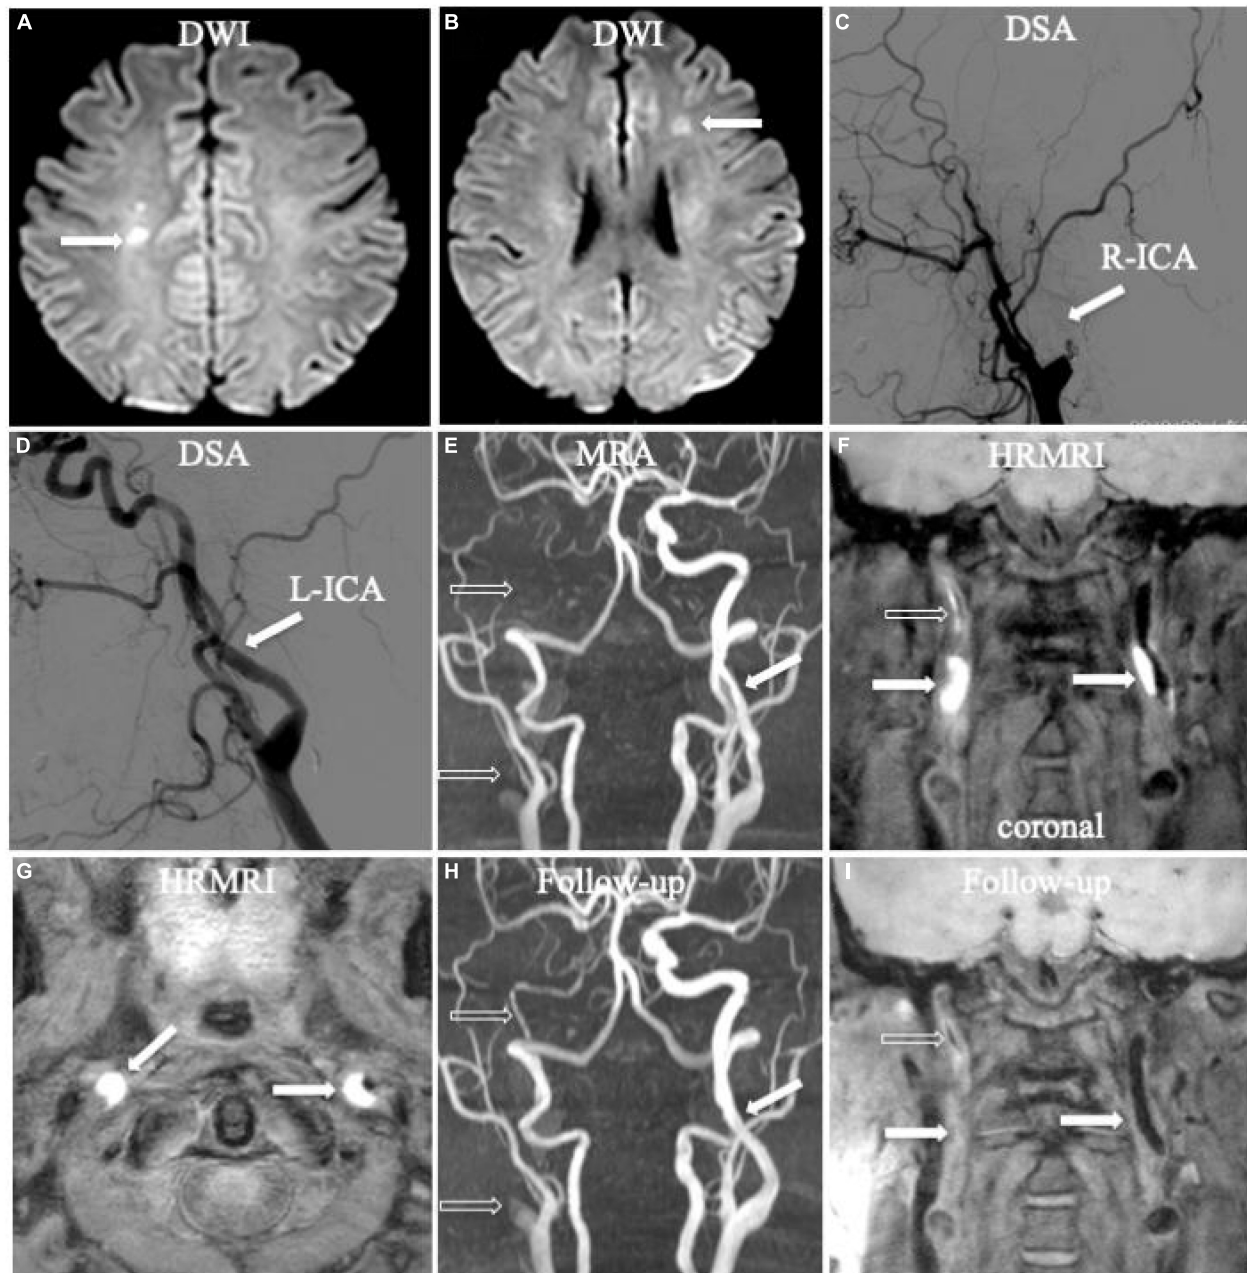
Bilateral acute ischemic stroke associated with dissection in the internal carotid arteries (ICA) bilaterally. Diffusion-weighted imaging (DWI) showed acute ischemic stroke in bilateral hemispheres (A,B, arrow). Digital subtraction angiography (DSA) only showed occlusion in the right ICA (C, arrow) and mild irregular stenosis in the left ICA (D, arrow) without any direct dissecting signs. Initial magnetic resonance angiography (MRA) displayed occlusion (E, empty arrow) in the right ICA and mild irregular stenosis in the left ICA (E, arrow), similar as the founding on DSA. Initial coronal T1-weighted high-resolution magnetic resonance imaging (HRMRI) demonstrated a T1-hyperintense intramural hematoma (F, arrow) in the proximal C1 segments of the ICA bilaterally and a T1-hyperintense intraluminal thrombus in the middle and distal right ICA (F, empty arrow). Transverse HRMRI presented with typical crescent-shaped intramural hematomas (G, arrow). Follow-up MRA showed partial recanalization in the middle and distal right ICA (H, empty arrow) and a nearly normal lumen in the left ICA (H, arrow). Follow-up coronal HRMRI exhibited disappearance of the T1-hyperintense intramural hematoma (I, arrow) in the ICA bilaterally and T1-hyperintense intraluminal thrombus (I, empty arrow) in the right ICA.
